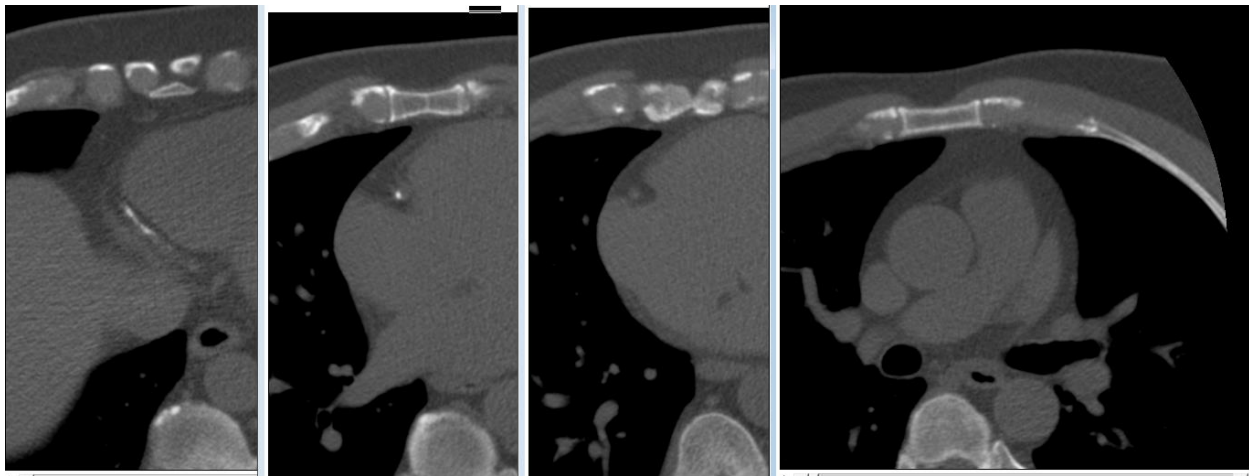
Four slices of cardiac CT showing calcified plaque in coronary artery.
